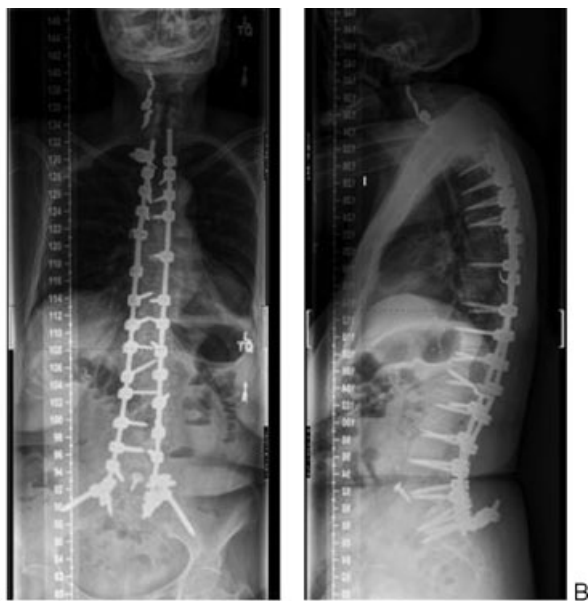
Postoperative (A) anteroposterior and (B) lateral standing X-ray.
